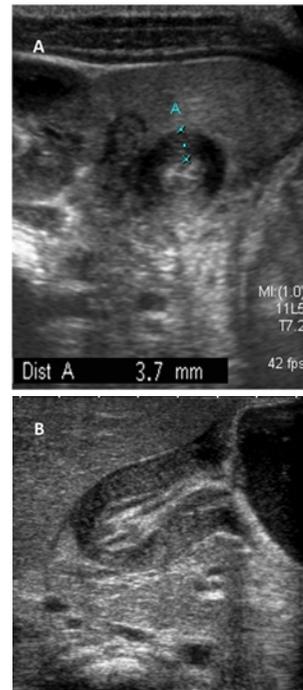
(A): A 6 week old child presenting with non-bilious vomiting. Transverse sonogram reveals 'target' appearance of the pylorus with thickened hypoechoic muscular layer, suggestive of HPS. (B): Longitudinal image in the same patient reveals elongated and thickened pylorus- 'the cervix sign'.
